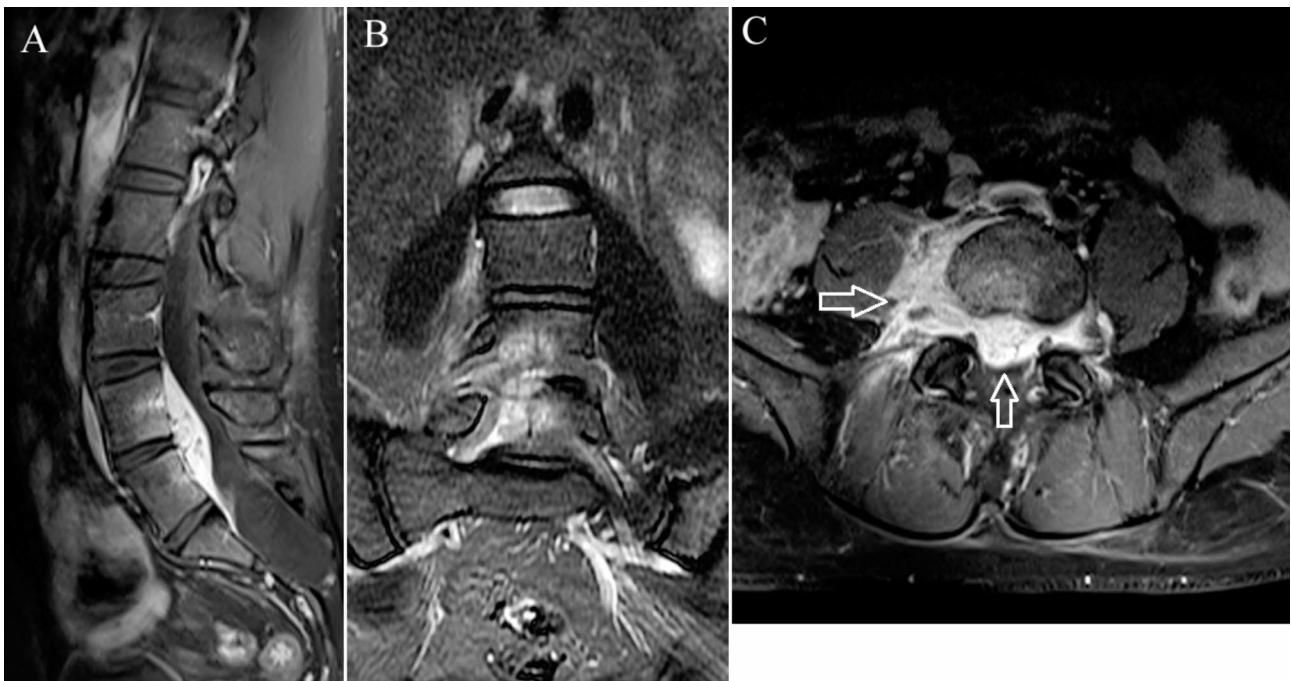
Contrast-enhanced T1-weighted imaging of the same patient as in Fig. 1. (A) The abscess and the L4 and L5 vertebral bodies exhibit enhancement on the sagittal imaging. (B) Coronal imaging also demonstrates L4-5 vertebral body enhancement. (C) Both the epidural and paraspinal components of the abscess show considerable homogeneous enhancement on the axial imaging (arrow)
